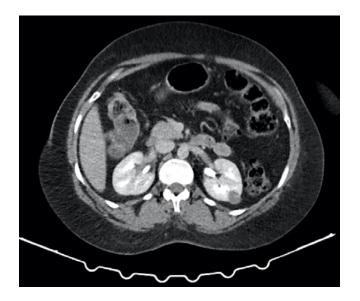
Axial view of the contrasted CT scan shows a left mid-pole cortical renal cyst with slight heterogenous attenuation (Bosniak III cyst)
